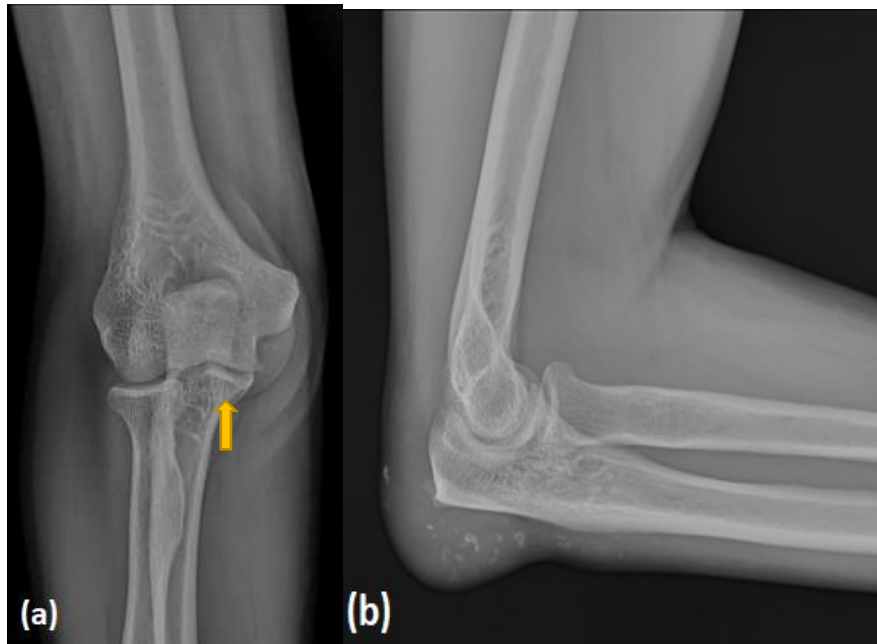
Radiographs (a) Antero Posterior (AP), (b) lateral show the preserved bone density of the bones. There are multiple calcified tophi seen in the olecranon bursa without adjacent erosion/destruction of the olecranon process (Fig. 2b).
